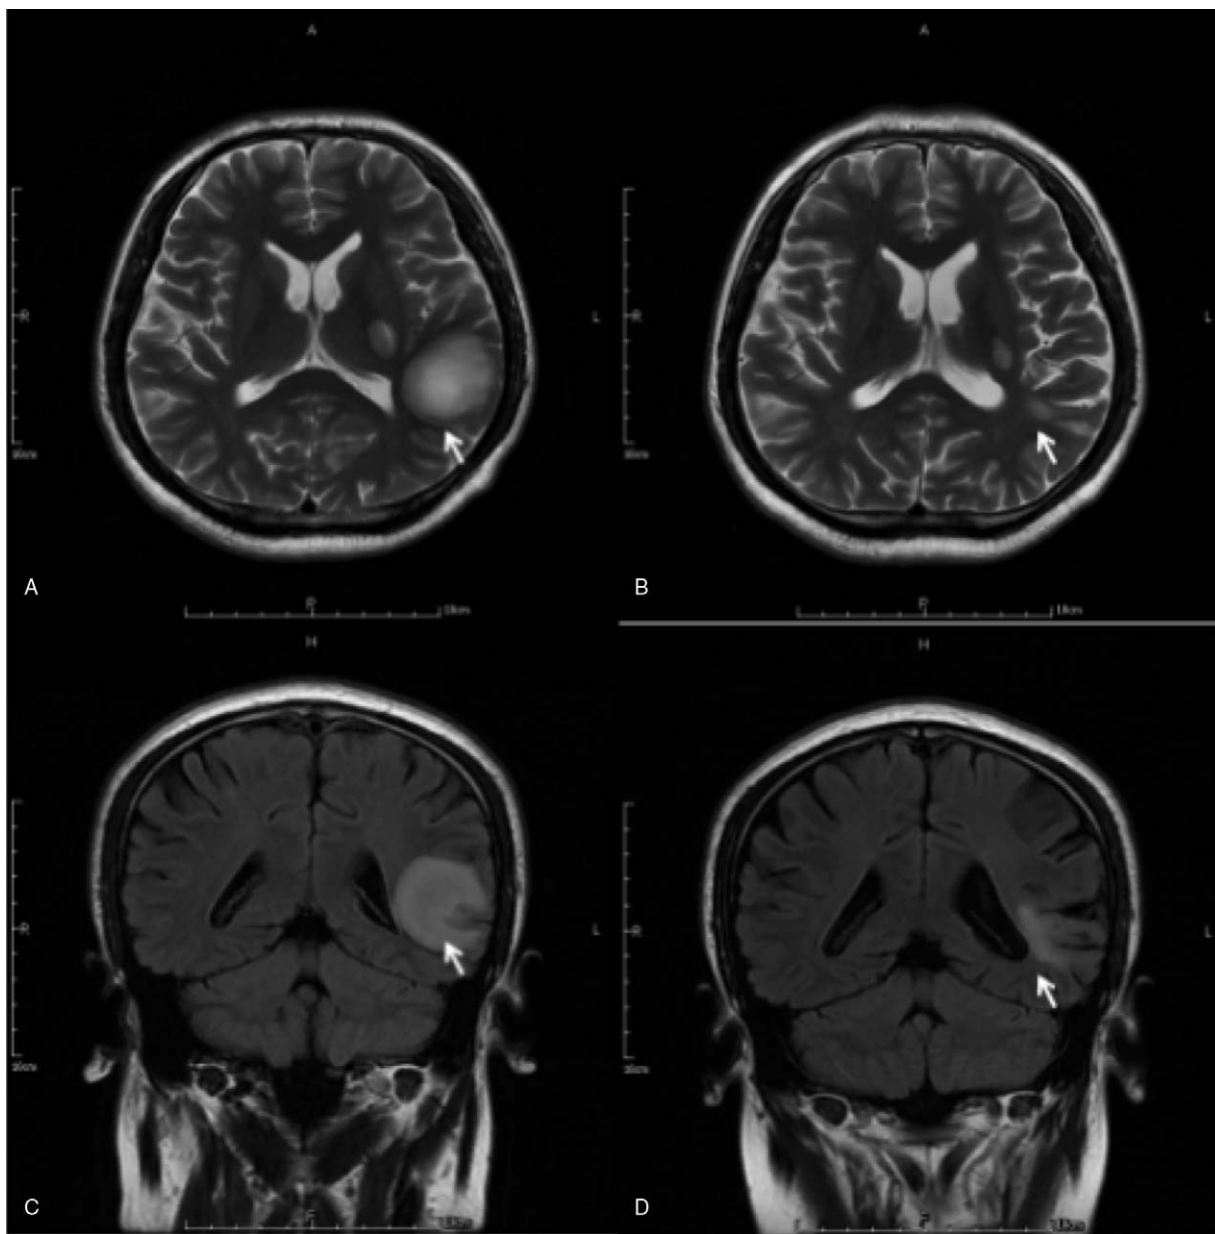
A: horizontal scan, C: coronal scan. Brain MRI showed multiple oval T2 signals in left basal ganglia region and left temporal lobe. The larger lesion which located in the left temporal lobe was $3.8 \times 3.6 \times 3.3$ cm in size and showed incomplete annular enhancement. B: horizontal scan, D: coronal scan, 3 months after treatment.
